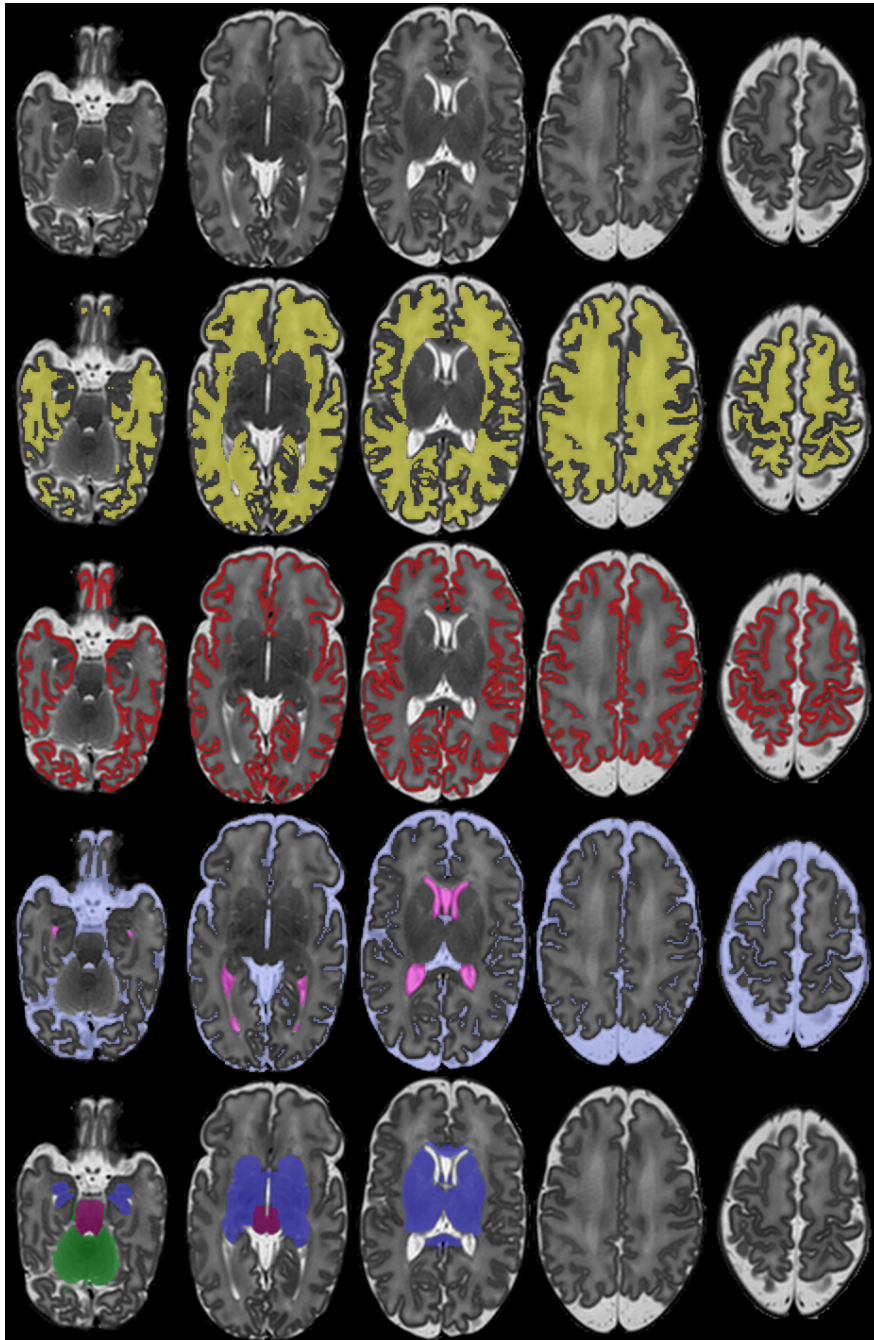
Example tissue segmentation of a neonatal MRI acquired at 36 weeks PMA with the method proposed in this thesis (second row: WM label, third row: GM label, fourth row: CSF labels, fifth row: subcortical GM labels).
